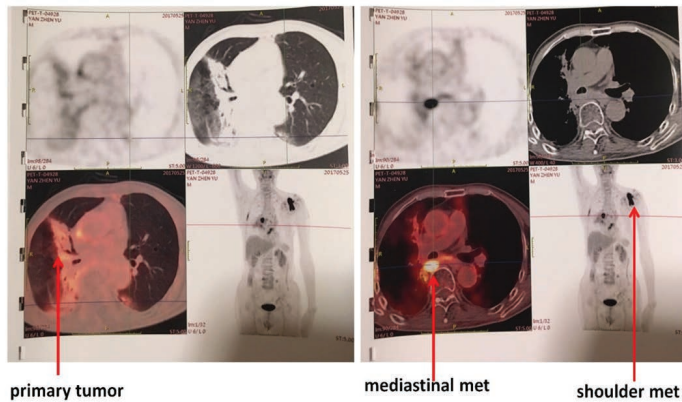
The pre-surgery PET-CT showing metabolically active sites in the lung cancer case presented in section 7 of the text. The location and metabolic signals of three tumors (the primary tumor, the mediastinal lymph node metastasis and the shoulder metastasis) are marked by arrows in the graph. The SUVmax for these tumors are: primary tumor (2.3); mediastinal metastasis (7.5) and shoulder metastasis (7.9).
